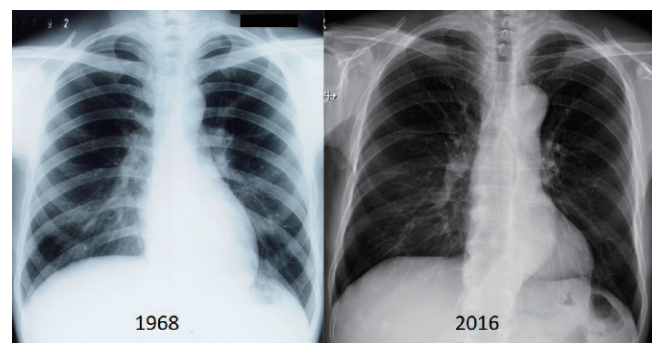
Chest x-ray photograph
